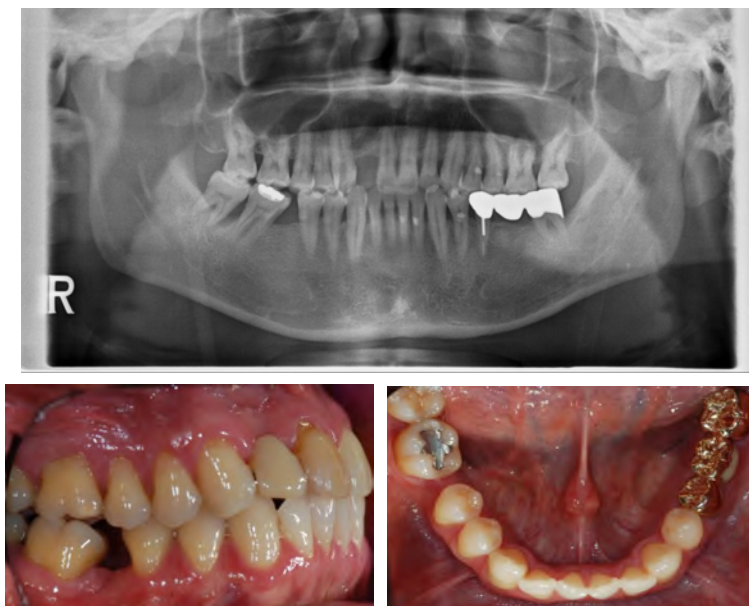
Pretreatment panoramic radiograph and intraoral photograph. Space reduction due to mesial tilting of the molar is observed.
